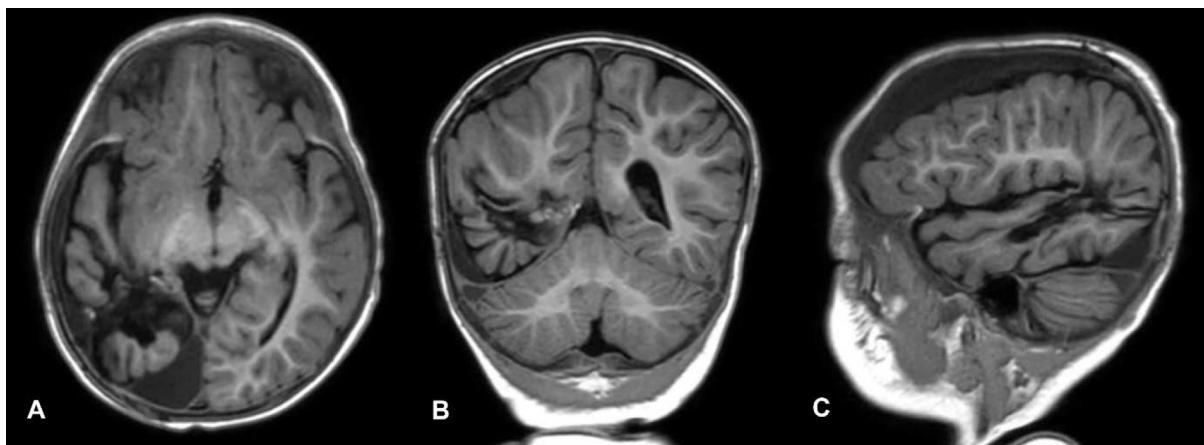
Follow-up T1-weighted magnetic resonance imaging of the brain demonstrating no evidence of tumor recurrence. (A) Axial T1-weighted image, (B) Coronal T1-weighted image, (C) Sagittal T1-weighted image.
